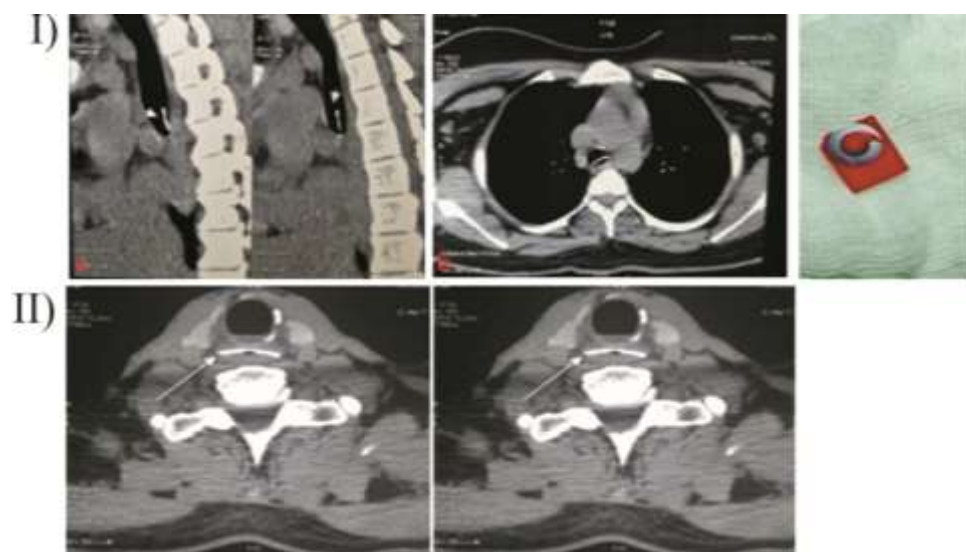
(I): a, b) CT scan of thorax shows sim card lodged at carina. c) Sim card after removal. (II): CT scan shows artificial denture.
